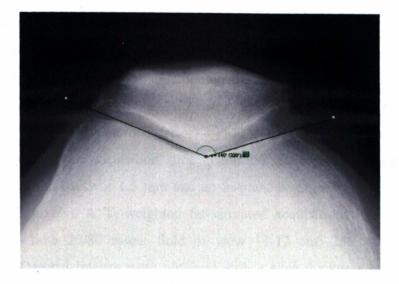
Skyline radiograph used to measure femoral sulcus angle. The femoral sulcus angle was defined by lines joining the highest points of the medial and lateral condyles and the lowest point of the intercondylar sulcus as previously described [323, 324]
